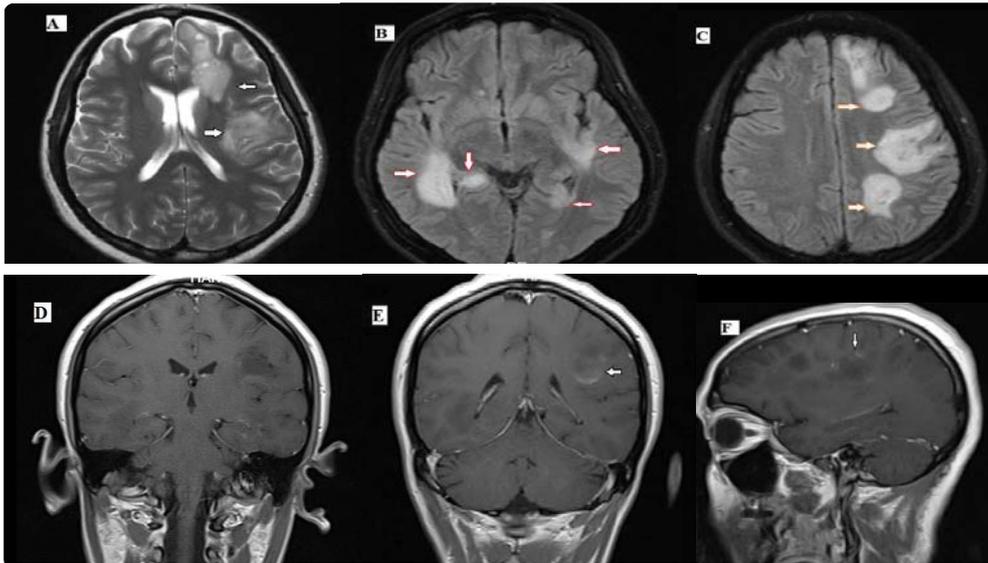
Repeated MRI after 3 weeks of hospitalization reveals similar hyperintense lesions on axial T2-weighted and FLAIR images with slightly gadolinium enhancement in T1-weighted (T1w) sequence (A-F, arrows).
